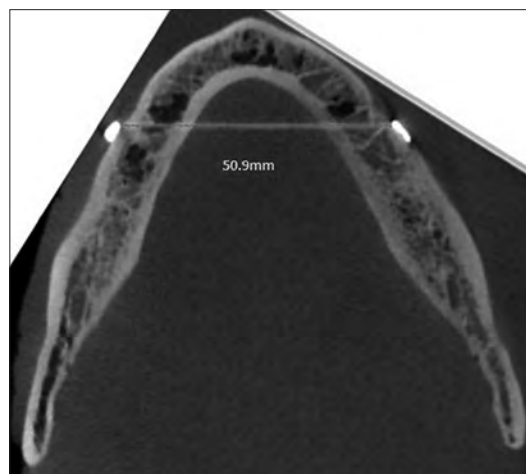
Linear measurement between right and left mental foramen obtained by CBCT in axial plane
